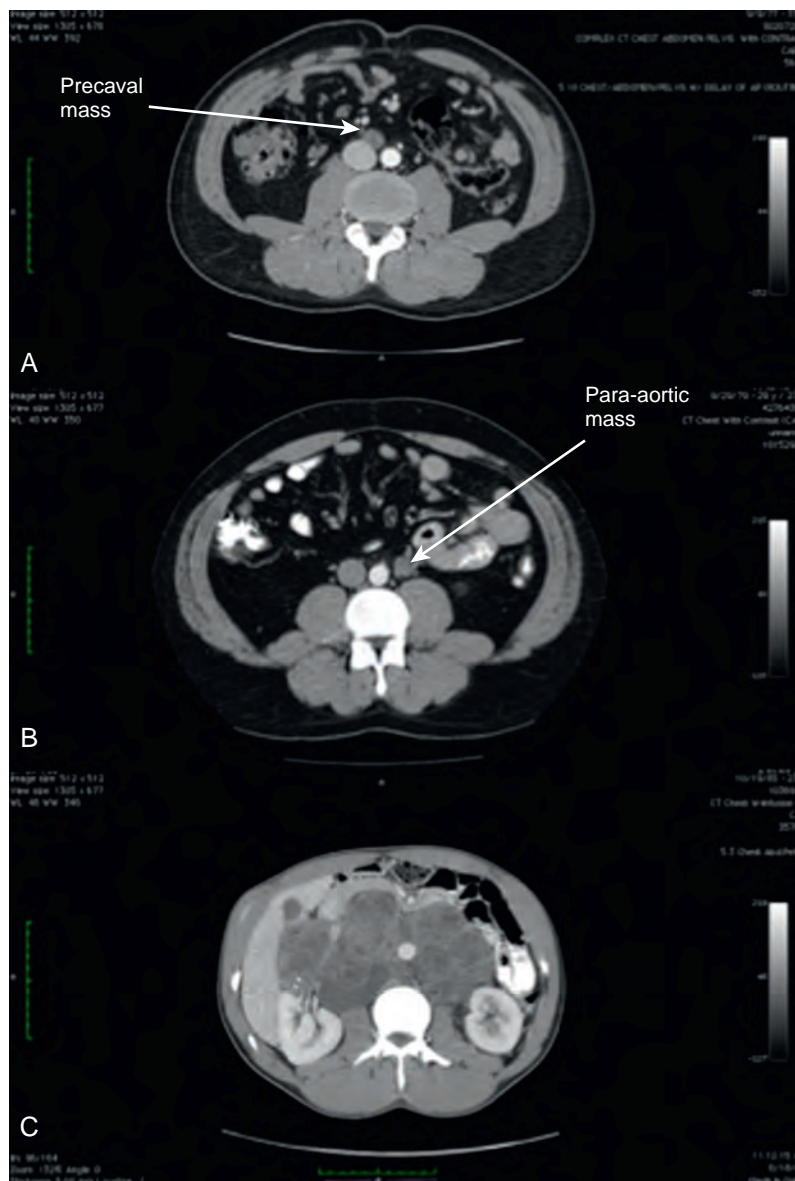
Computed tomography images of postchemotherapy residual retroperitoneal masses. A, This patient could be considered a candidate for modified right template postchemotherapy retroperitoneal lymph node dissection (PC-RPLND). B, This patient could be considered a candidate for modified left template PC-RPLND. C, This patient would require an extensive bilateral PC-RPLND.
